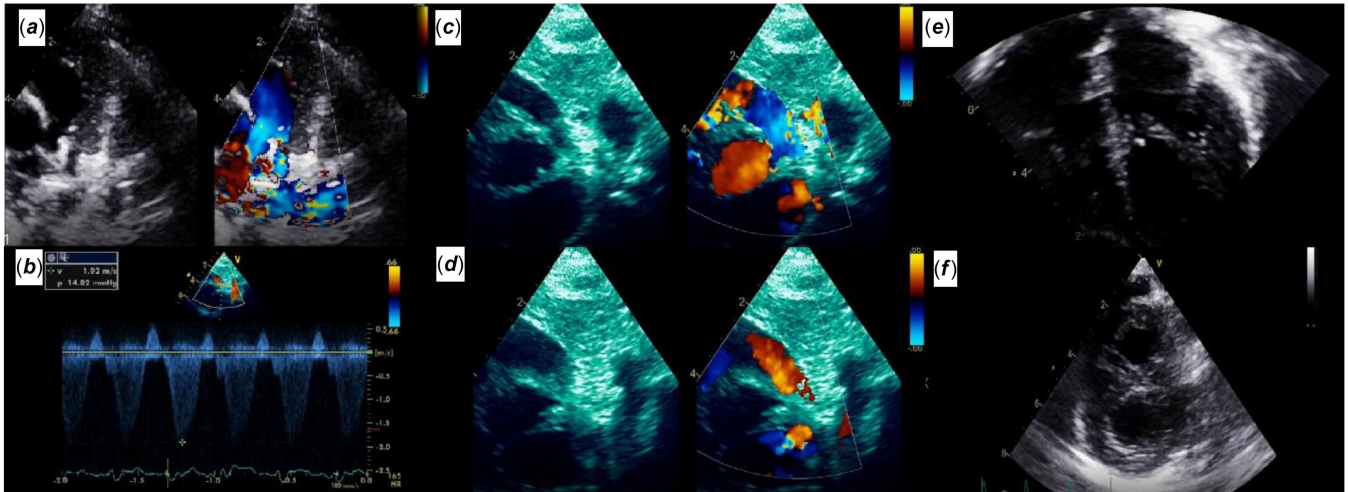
A. Parasternal short axis view (PSAX): Outflow tract with adequate flow. B: Pulsed Doppler; no stenotic gradient. C: PSAX: systole with antegrade flow. D: PSAX: diastole with free pulmonary insufficiency. E: Apical 4-Chamber: RV cavity larger than the beginning. F: PSAX at ventricular level; larger right ventricular cavity.
